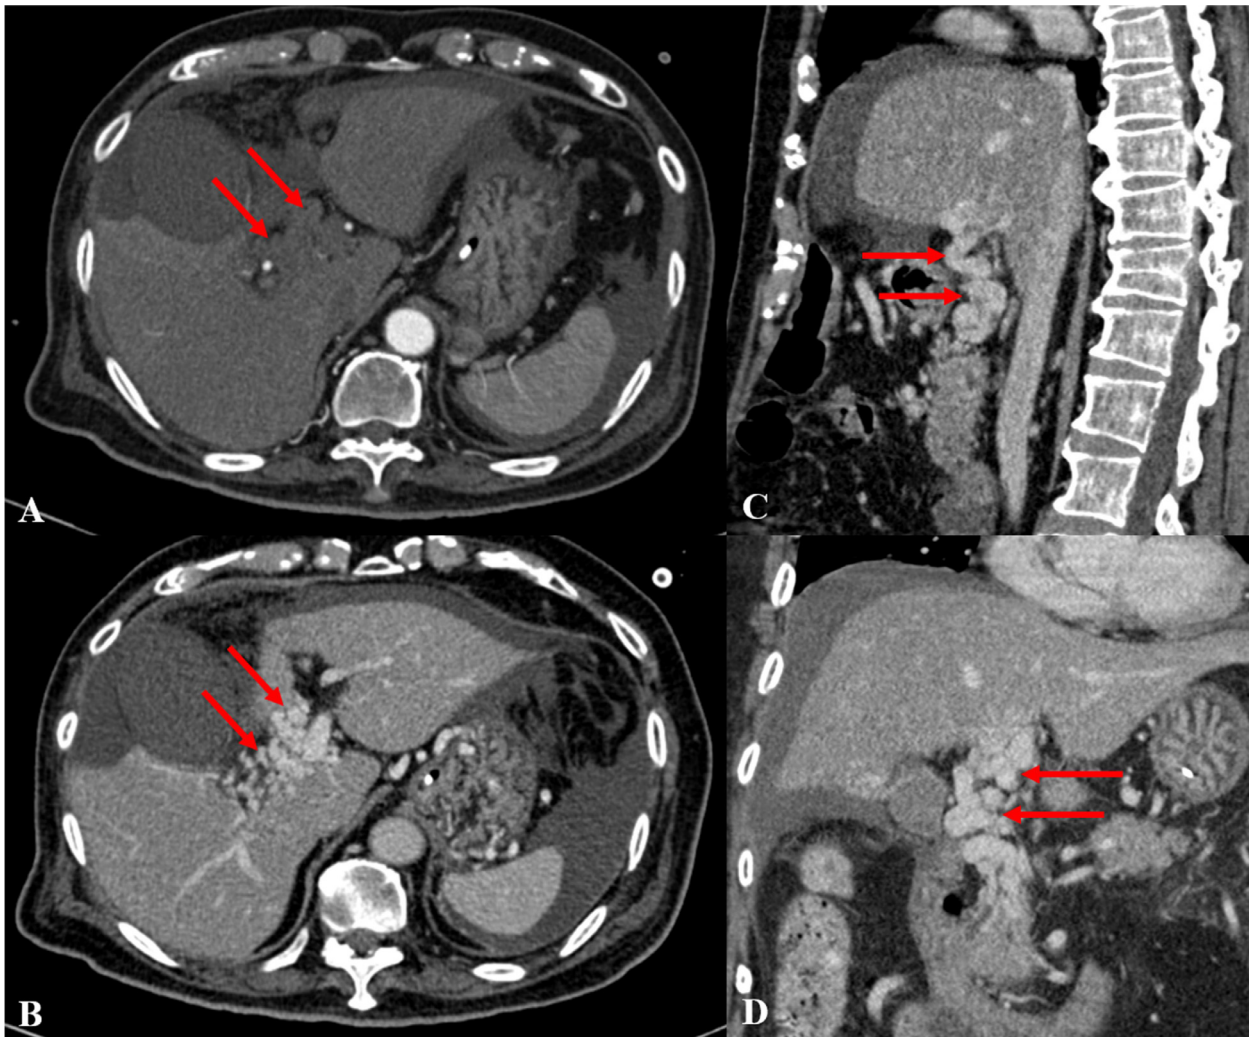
Axial CT scan through the hepatic hilum in the arterial phase (A) and portal venous phase (B). Sagittal (C) and coronal (D) reconstruction CT scan through the hepatic hilum in the portal venous phase. Numerous tortuous channels enhancing during portal venous phase and not during arterial phase (→), consistent with a diagnosis of portal cavernoma.
